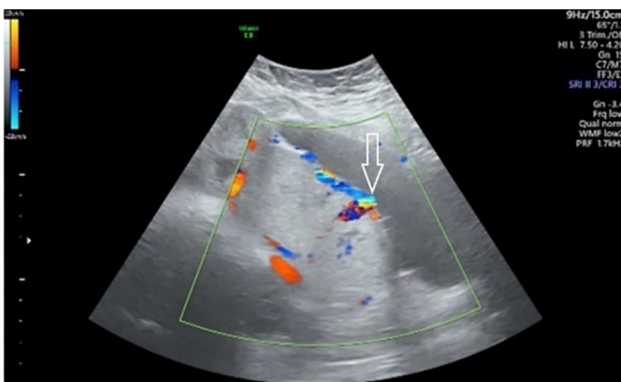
Transabdominal sonogram: bridging vessels between placenta and bladder (white arrow) in pregnant woman, 39 years old, 34 GW, obstetrical history: two abortions, two Cesarean sections, the last for placenta praevia associated with placenta percreta. GW: Gestational weeks.
